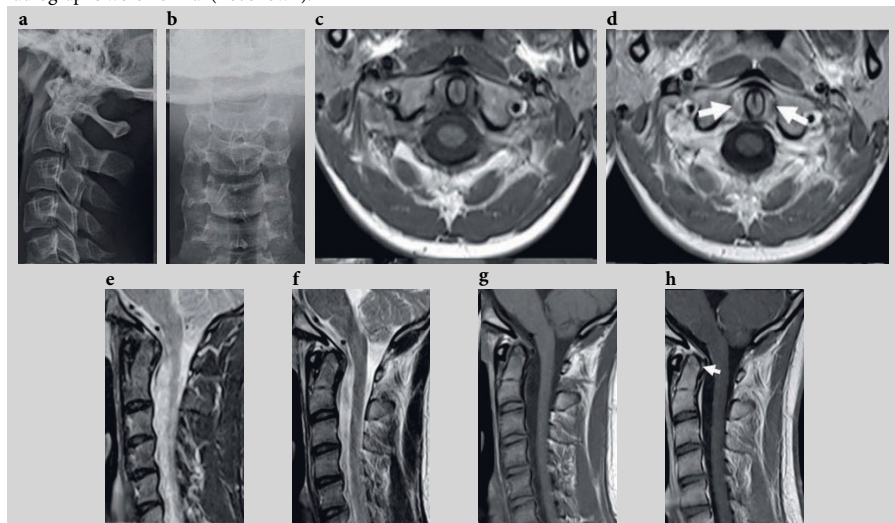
Conventional radiograph (X-ray) and magnetic resonance imaging (MRI) of the cervical spine of a patient with rheumatoid arthritis and neck pain. (a, b): Normal X-ray, without signs of C1/C2 luxation and without erosion at dens axis. (c-h): Axial T1-weighted pre-contrast (c) and post-contrast (d) MRI are displayed in the upper row. The lower row displays (e) sagittal T2-weighted; (f) short tau inversion recovery (STIR); (g) pre-contrast T1-weighted; and (h) post-contrast T1-weighted MRI. Enhancing synovitis is seen around the dens axis (arrows). No erosions are seen.
